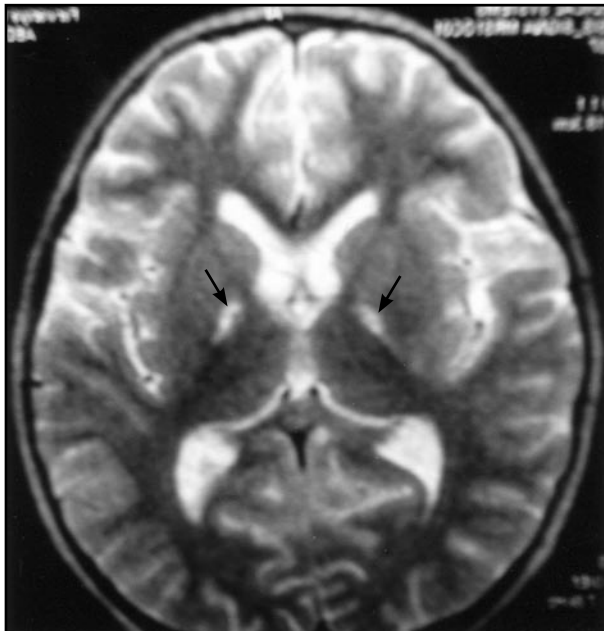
(a & b): T2-weighted axial (3a) and coronal (3b) MRI brain images showing multiple lesions of high signal intensity in thalamic, basal ganglia and internal capsule regions bilaterally
